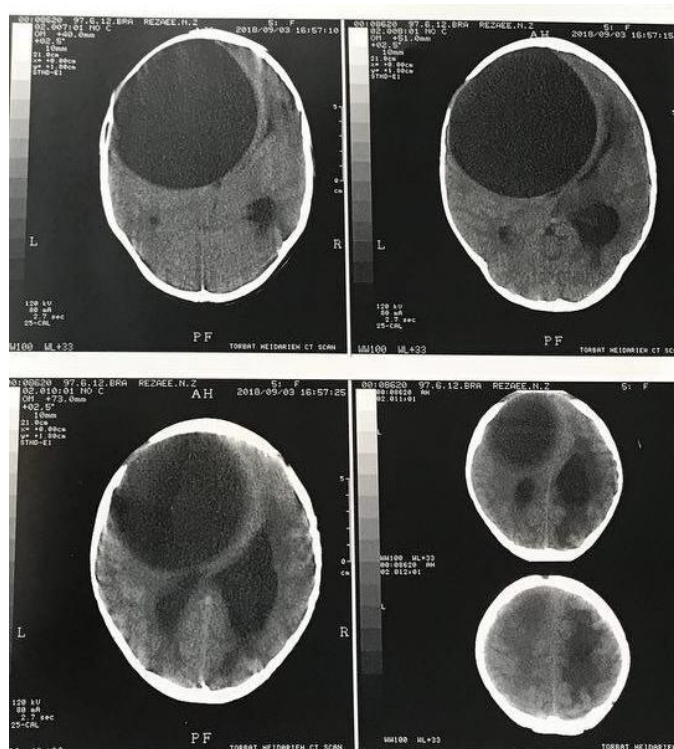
The first head CT scan of the patient in axial view.
